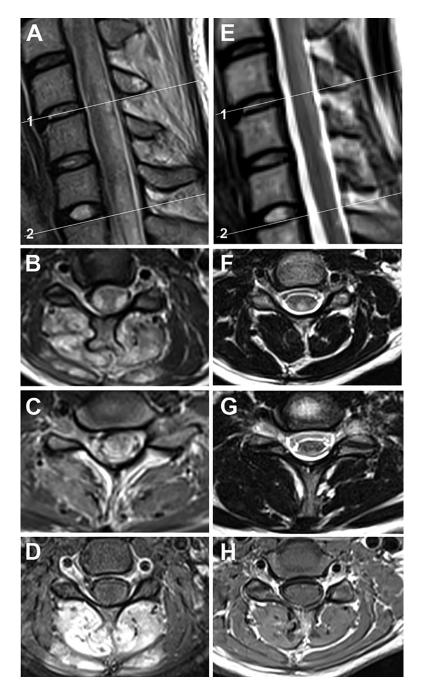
(A) Sagittal T2-weighted 1.5 Tesla MR image demonstrates swelling of the spinal cord and dorsally pronounced hyperintense signal changes extending from C3 to Th1. (B) The axial T2-weighted sequence at C4/5 level (corresponding to line 1 in A) shows the increased signal dorso-laterally, mostly affecting the lateral columns including the corticospinal tract and sparing most of the gray matter and the dorsal columns. Swelling and homogeneous T2-weighted hyperintense signal of the spinalis cervicis, multifidus, semispinalis capitis, and semispinalis cervicis muscles on both sides is depicted. (C) At C6/7 level an axial T2-weighted image (corresponding to line 2 in A) shows a more diffuse pattern of hyperintense signal changes in the spinal cord with less pronounced signal changes in paraspinal muscles compared to B. (D) The axial fat-suppressed contrast-enhanced T1-weighted sequence at C4 level demonstrates the homogeneous contrast enhancement within these muscles. Of note, there is no contrast enhancement in the affected spinal cord. (E) The sagittal T2-weighted 14 weeks later shows reduced swelling of the spinal cord and a decrease in T2-weighted hyperintense changes. (F) Axial T2-weighted image at C4/5 level (corresponding to line 1 in E) shows hyperintense signal changes confined to the dorsal columns. Edema-like signal changes within the paraspinal muscles disappear and respective muscles are moderately atrophied (G) The axial T2-weighted image at C6/7 level (corresponding to line 2 in E) depicts areas of low signal intensity within the central spinal cord indicative of blood degeneration products. (H) In the axial contrast-enhanced T1-weighted sequence at C4 level 14 weeks later contrast enhancement within paraspinal muscles is hardly detectable. The size of affected muscles is reduced.
